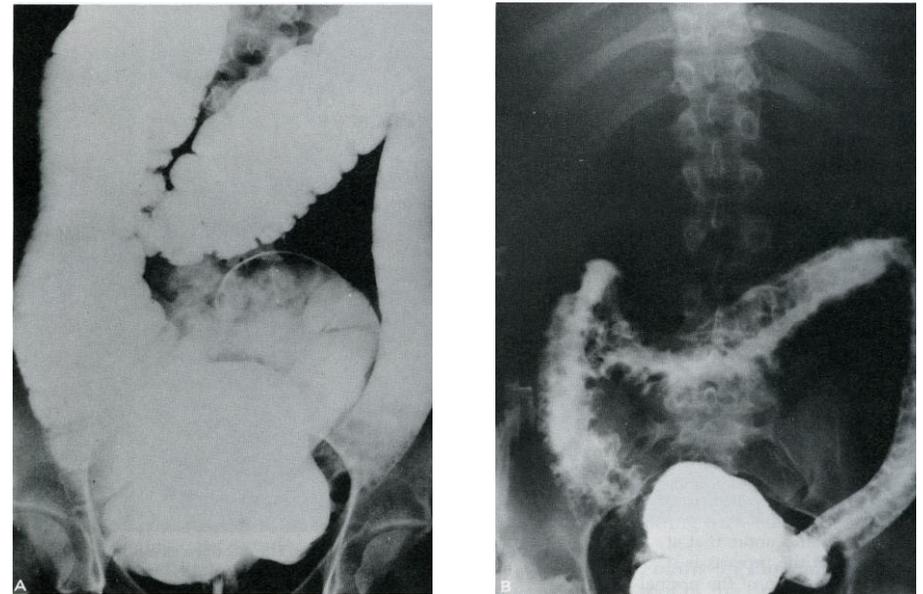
Rapid progression of ulcerative colitis. The x-rays in A were taken 3 weeks before those in B. During that time this young girl lived at home under some stress. One of the mysteries of ulcerative colitis is how it can so completely destroy a bowel as this so rapidly.
